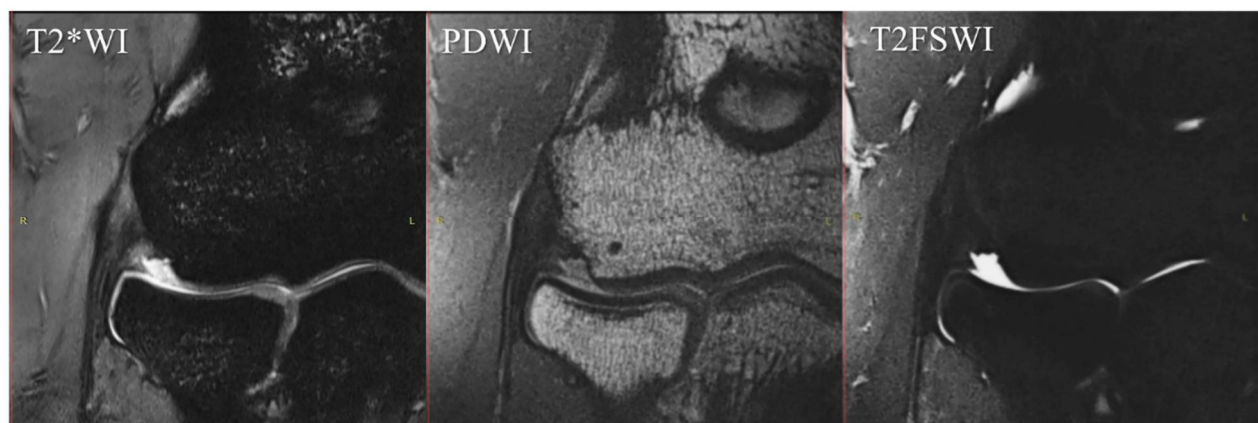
Differences in signal intensity of the CET/LCL complex by sequence. The unaffected elbow of a 32-year-old male. These images are same-level slices of the MRI coronal section in each sequence. In this case, T2*WI shows a high signal at the CET/LCL complex despite a complete low signal in the sequence of PDWI and T2FSWI. MRI, magnetic resonance imaging; T2*WI, T2*-weighted images; PDWI, proton-density-weighted images; T2FSWI, T2 fat-saturated weighted images; CET, common extensor tendon; LCL, lateral collateral ligament.
